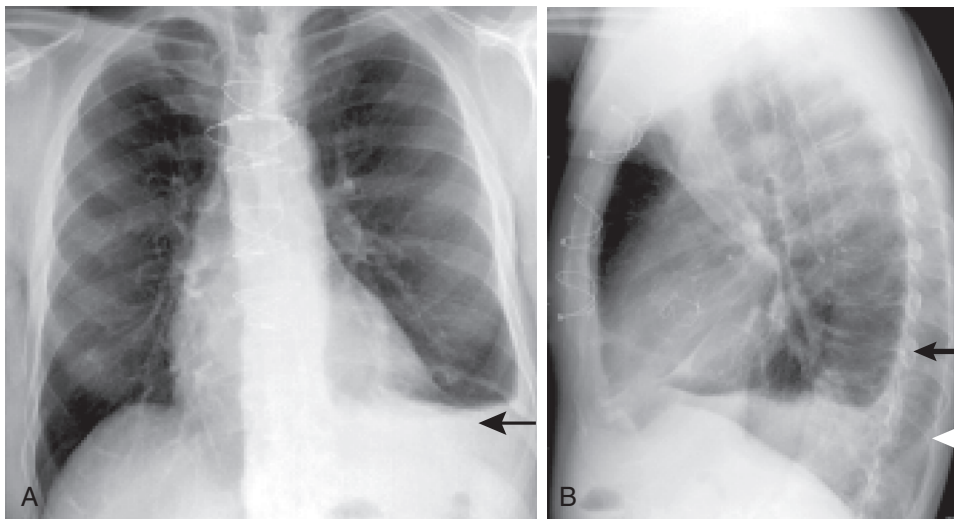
Standard upright chest radiographs of a 74-year-old man who has undergone aortic valve replacement. A, PA view showing the median sternotomy wires, a left pleural effusion (arrow), and a normal pulmonary vascular pattern. B, Lateral view. Note that the right ribs (white arrow) are magnified in comparison to the left (black arrow), and the effusion can be localized to the left. Also note that the gastric air bubble is displaced inferiorly (PA view) and anteroinferiorly (lateral view), indicative of an enlarged left ventricle.
